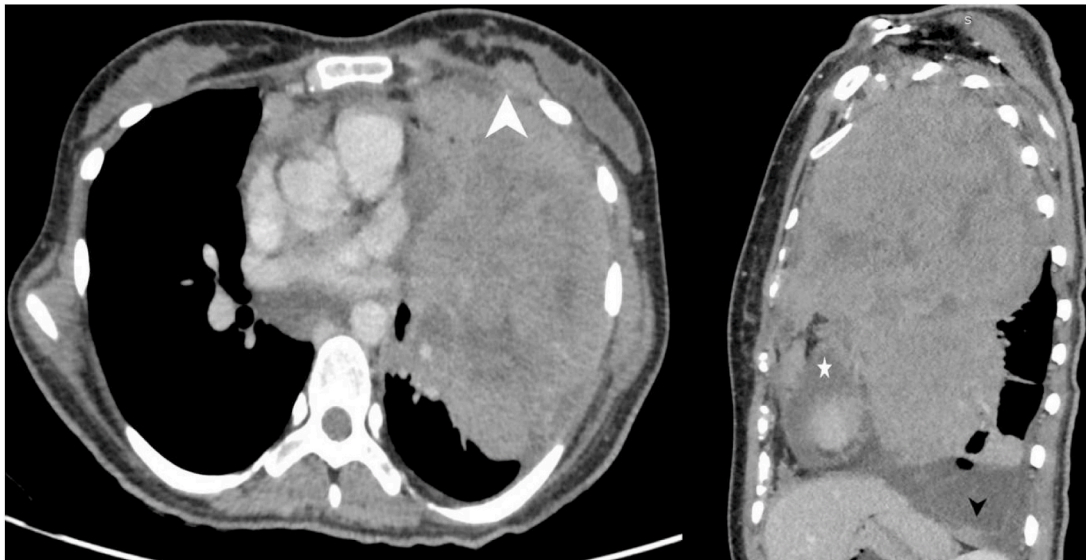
(a, b): Post contrast CT thorax images in axial and sagittal sections. Extra thoracic extension into left breast seen (White arrow head). Pericardial (star) and pleural effusion with deposits noted (Black arrowhead).
